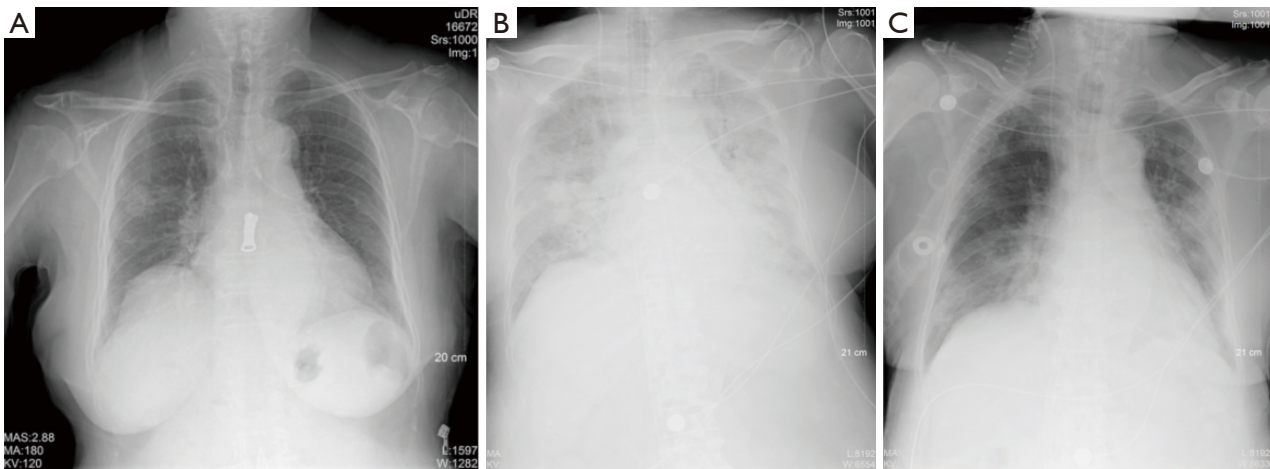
Chest X-ray images of the patient. (A) The chest radiograph on January 26 showed that the inflammation of the right lung and interstitial changes of both lungs, supporting COVID-19-infected. (B) The chest radiograph on February 8 showed that the inflammation of both lungs was significantly worse than before, and “white lung” changes were observed. (C) The chest radiograph on February 17 showed that the diffuse inflammation of both lungs, local lesions in the lower right lung field were slightly absorbed than before, and bilateral lung exudation was improved from before.
